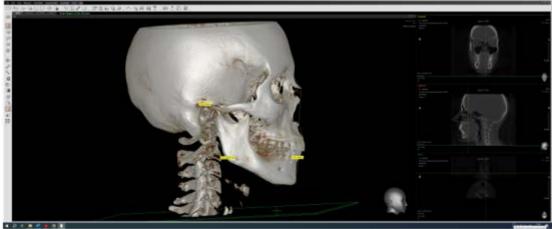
The software used for conducting craniometric analysis of CT scan results includes:
